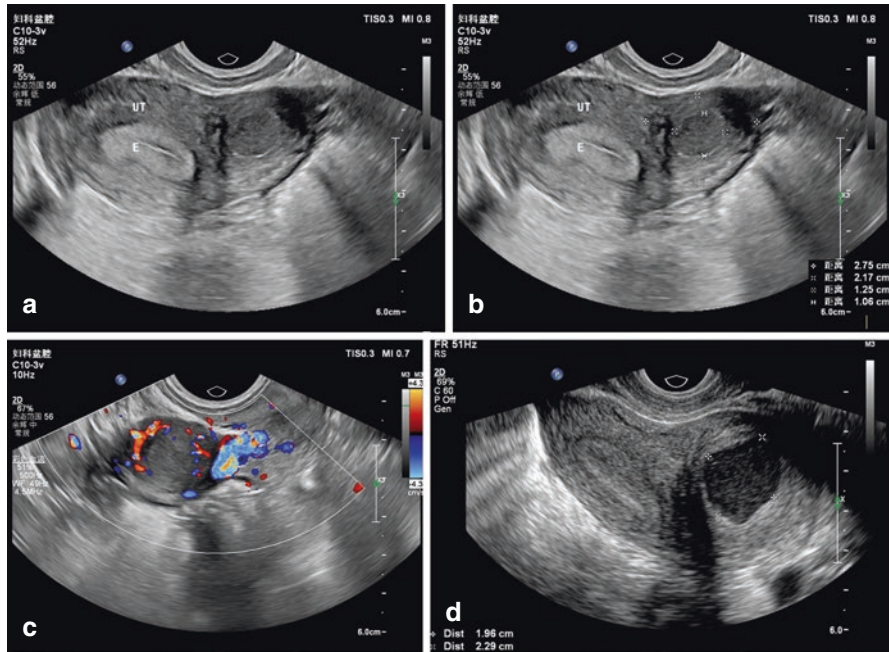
(a-d): Transabdominal and transrectal ultrasound images of cystic adenomyosis. (a-c) are transabdominal images with transvaginal probe placed on the abdomen. (a and b) show a mixed echo mass at the left wall of the uterus near the left corner of the uterus. The central area of the mass is a non-echo area with poor sound transmission. Thick echogenic areas are surrounding the anechoic area. In the hypoechoic area, the size of the entire lesion is 2.8 cm × 2.2 cm, and the size of the non-echo area is 1.3 cm × 1.1 cm. The boundary between the lesion and the normal muscular layer is unclear. (c) is a CDFI image of this case, showing a surrounding blood flow signal around the lesion. (d) is a transrectal ultrasound image of this case at the time of re-examination 10 months later. It can be seen that the frost glass in the non-echoic area of the center of the lesion is more typical, with a size of 2.3 cm × 2.0 cm
